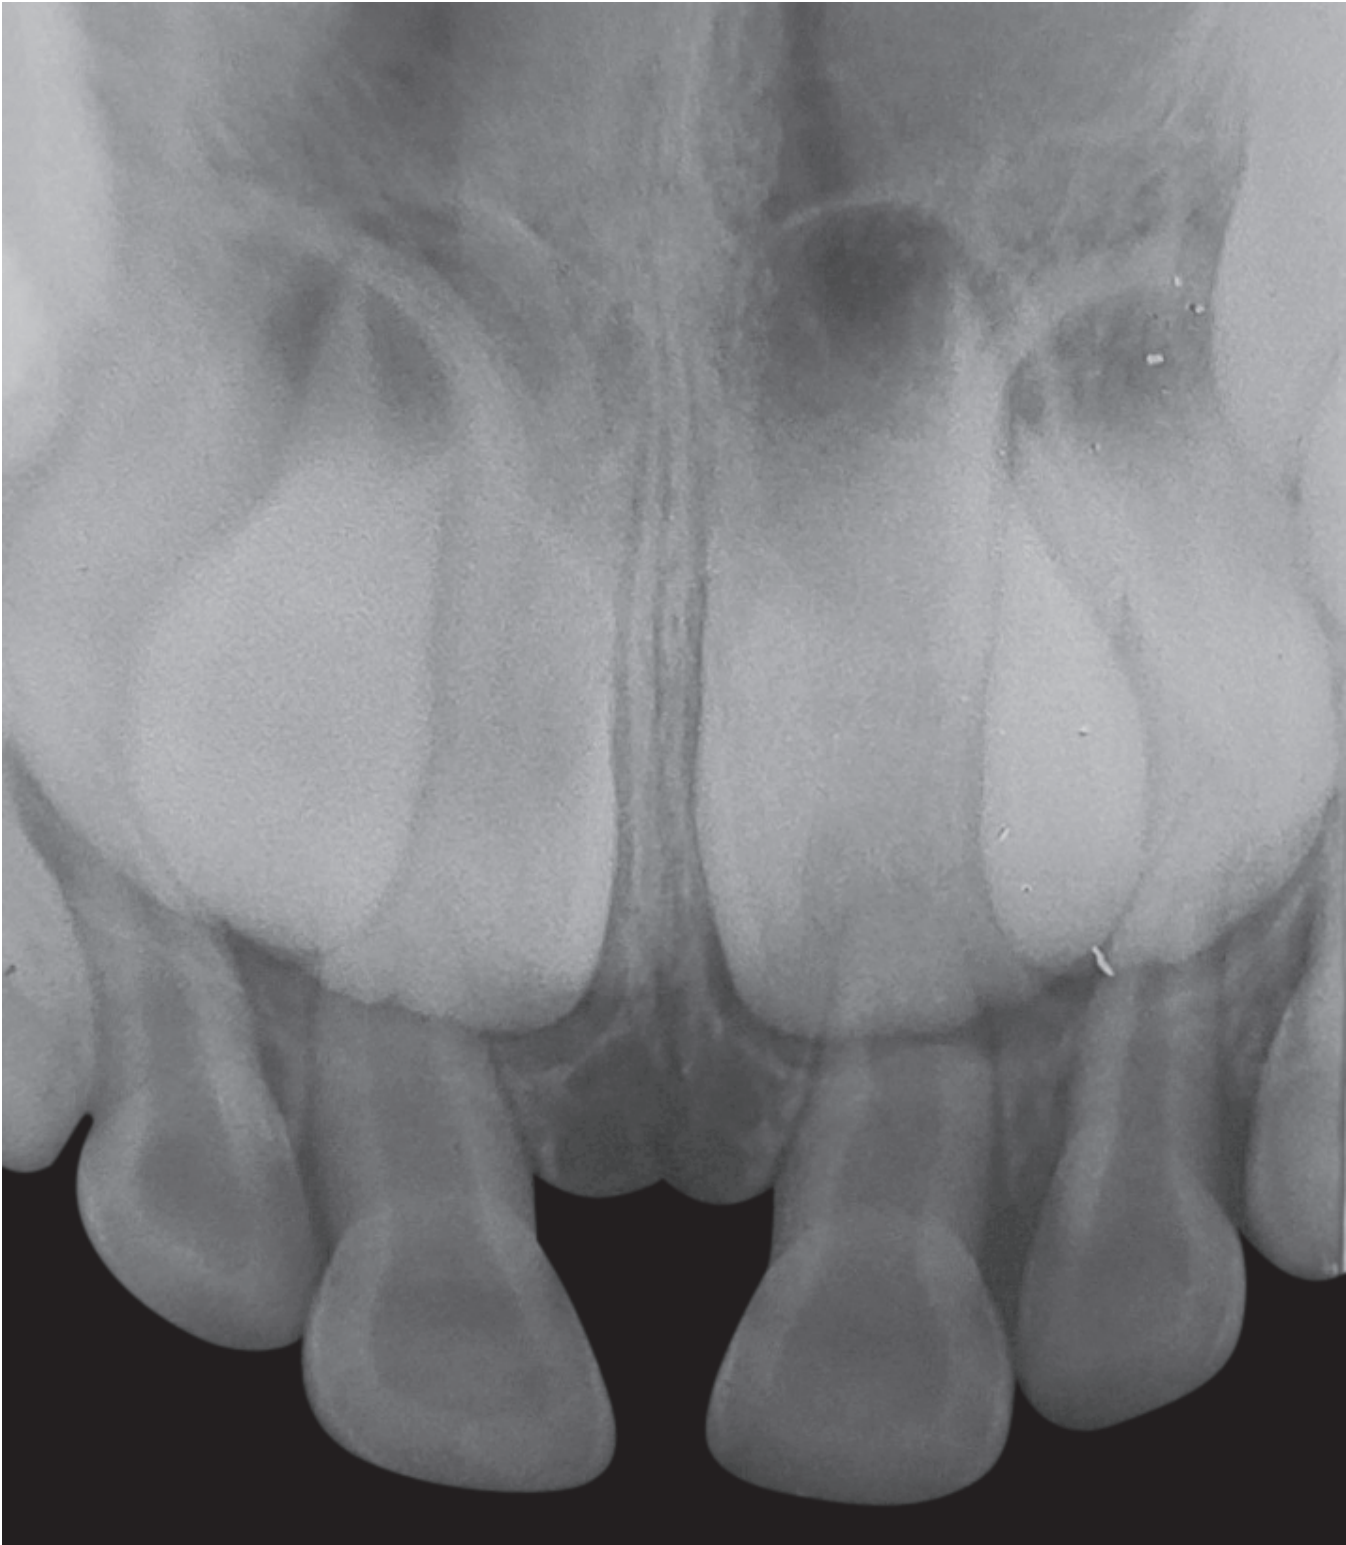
Intraoral periapical radiograph showing normal radiographic appearance of the age without any bony or hard tissue changes with respect to the lesion
